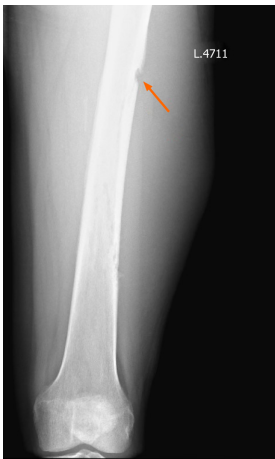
An X-Ray of the left thigh. Orange arrow indicates start of destruction of the femur.
